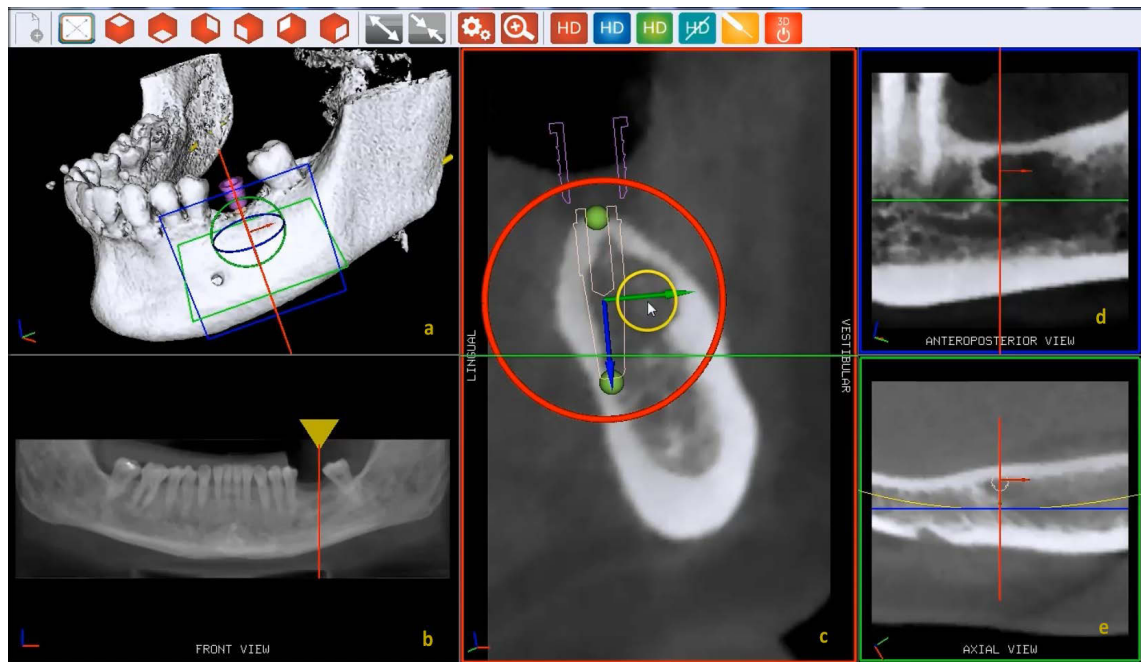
Virtual planning stage in the developed software application: (a) three-dimensional volume rendering; (b) orthopantomographic volume section; (c) vestibulo-lingual volume slice hosting the main implant positioning handles; (d) antero-posterior volume slice; (e) axial volume slice.
